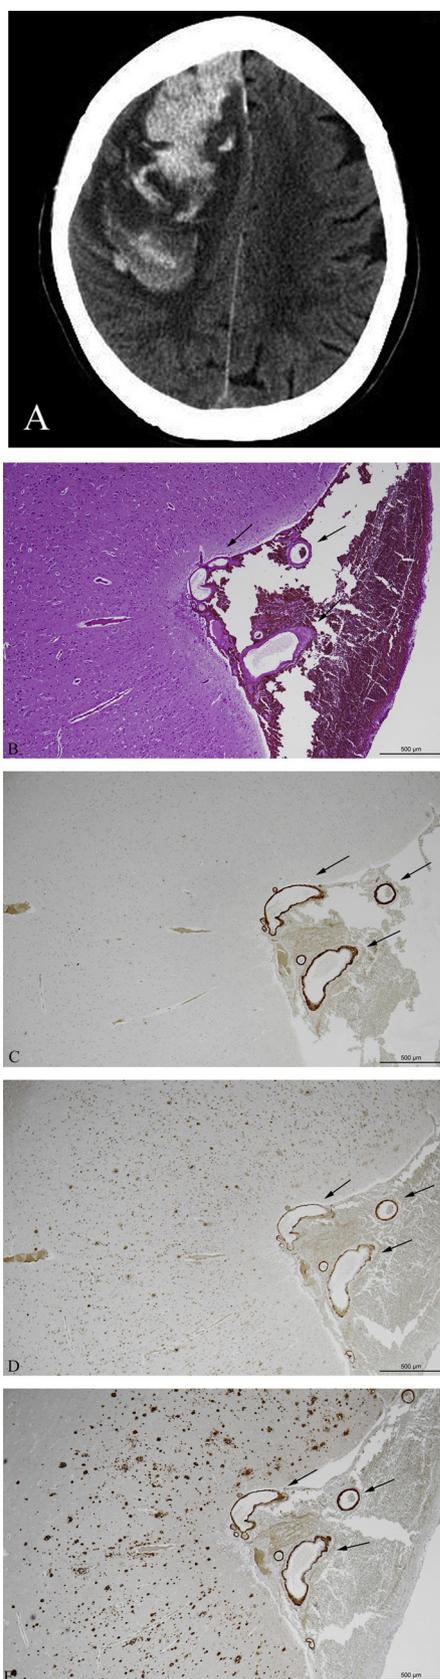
A: A non-contrast computed tomographic axial image is shown for a 78-year-old patient demonstrating a large frontal acute intracerebral hemorrhage. B: Sections of the evacuated hematoma showing brain parenchyma and vessels with intimal thickening (arrows) (HE). C: Aβ40 immunoreactivity in vessel walls confirming the presence of cerebral amyloid angiopathy (CAA) (arrows). D and E: Prominent Aβ-immunoreactive senile plaques and CAA vessels are seen (arrows) (Aβ42 and Aβ11–28).
